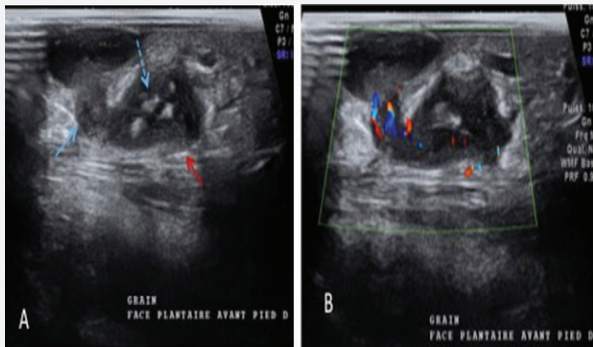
Ultrasound sections through cutaneous papules. (A) Diffuse subcutaneous hypoechoic oval ranges of different depths communicating through pertuis with more superficial ranges. Hyperechoic punctiform elements with angular contours, measured between 1 and 2mm corresponding to the grains. (B) Hyper vascularization at the Doppler. Note the presence of an overall thickening of the soft parts of the right forefoot.
